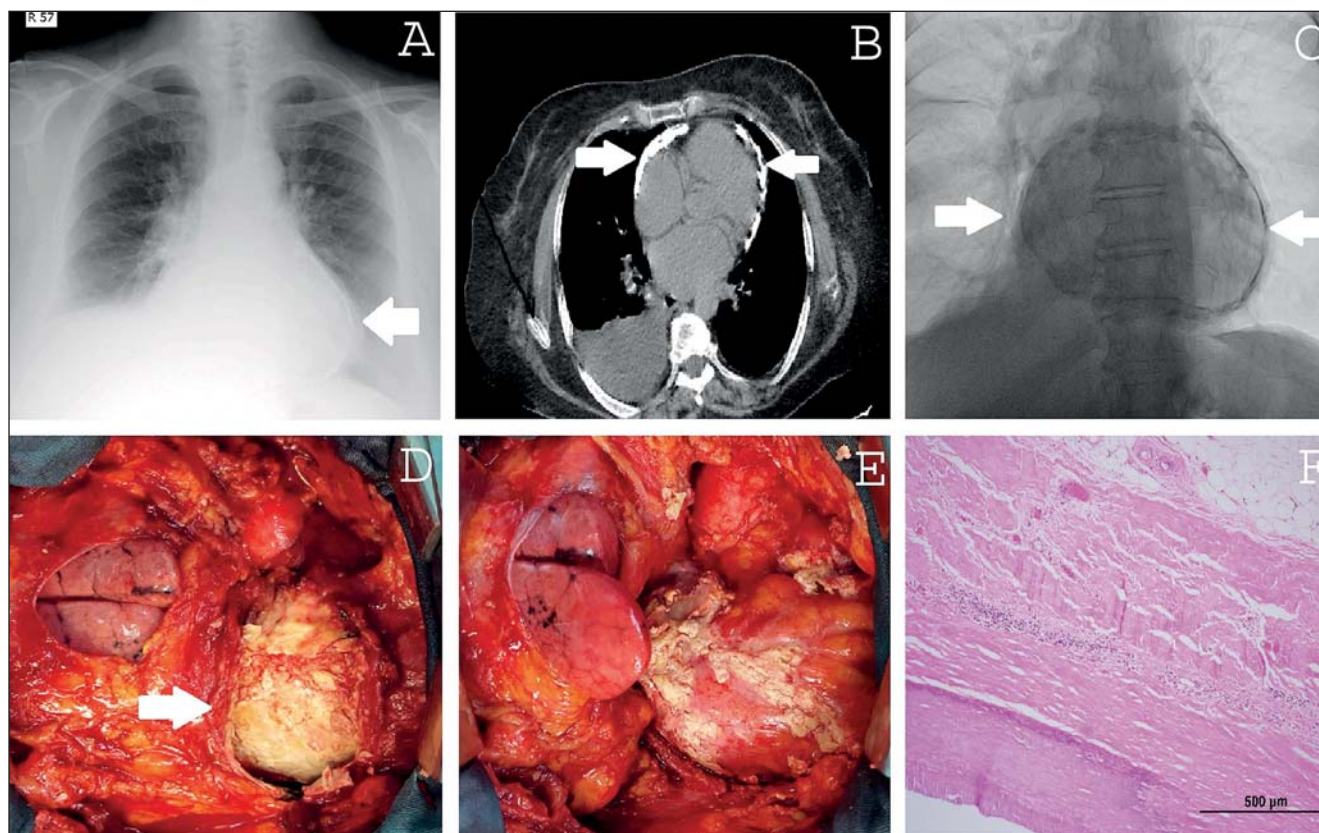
Pericardial calcification on the chest X ray (A), heavy pericardial calcifications on the computed tomography (B), pericardial calcifications on the right heart catheterisation (C), intra-operative image of the completely pericardial calcification (D), intra-operative image after the subtotal total pericardiectomy (E) and pathological examination of the tissue (F).
